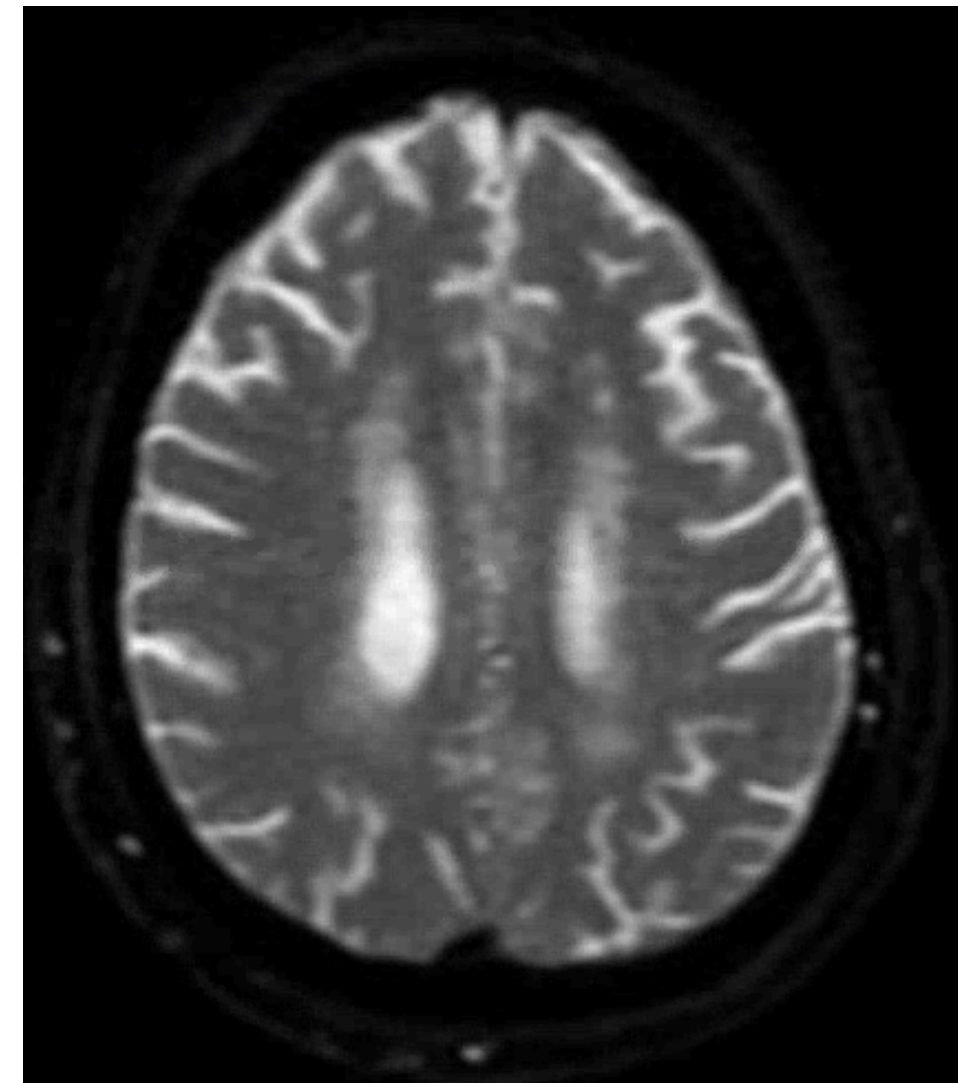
Patient 1 Brain MRI DWI with L with punctate foci of positive diffusion trace in high L centrum semiovale, Embolic.
